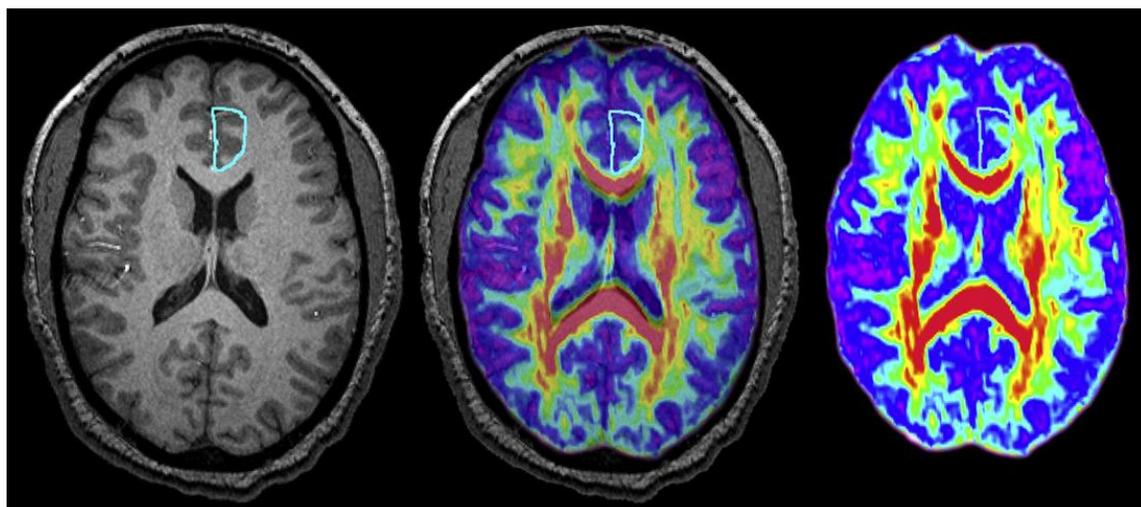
Depiction of Co-registration of Anisotropy Map with the T1-weighted Image. Left: axial MRI image with the left anterior cingulate gyrus traced. Center: fused image depicting the co-registration of the anisotropy map with the T1-weighted image. Right: FA map obtained with diffusion tensor acquisition. The color scale indicates FA values, as the highest FA values are seen in the corpus callosum and intermediate values are seen in the cingulum bundle.
